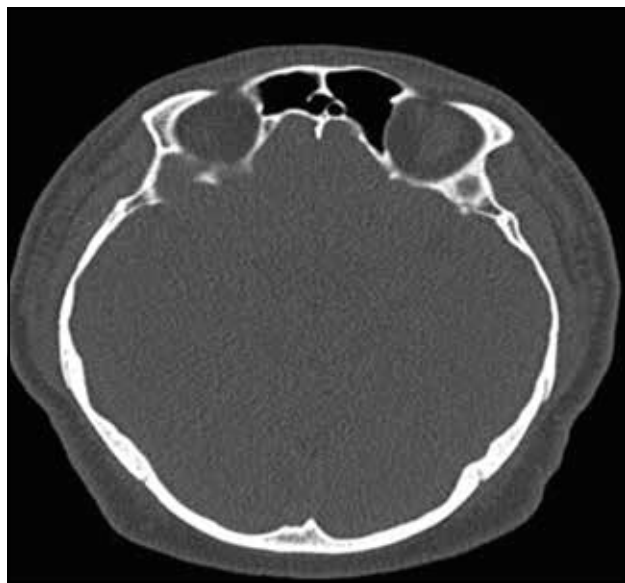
Cranio-facial CT (axial view), showing no lysis of the anterior wall of the frontal sinus (performed 6 months prior to the initial evaluation in our clinic).
